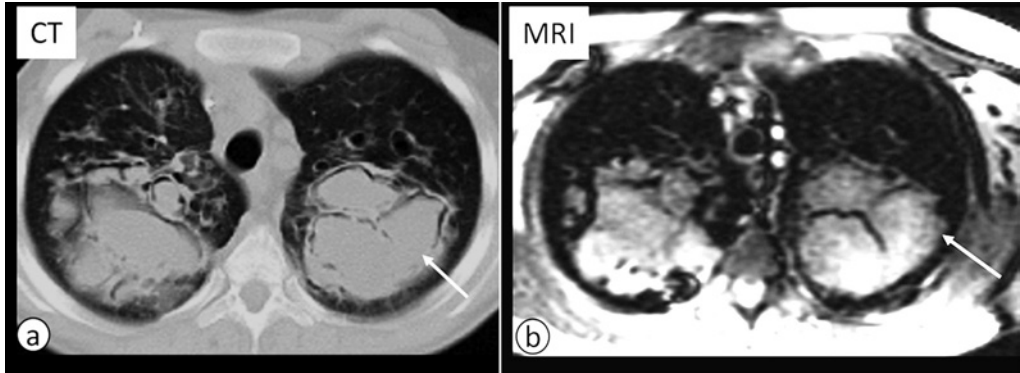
Aspergillomas infection in CF. CT (a) versus SSFP MRI (b) in 16 years old boy with end stage CF lung disease. Note widely dilated bronchi filled with thick mucus and aspergillomas (white arrow).
